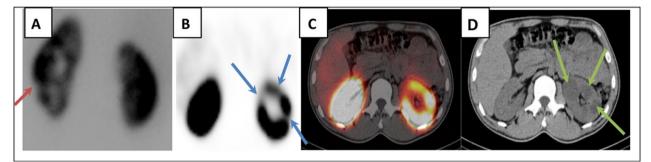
A 25-year-old, male patient, presented with left loin pain. A ^{99m}Tc-DMSA planar image (posterior view) demonstrating equivocal defect at the lower outer aspect of the left kidney (red arrow), B axial SPECT image revealed multiple left cortical defects (blue arrows), C the corresponding fused SPECT/CT and D the CT images shows that these defects are corresponding to multiple simple cortical cysts (yellow arrows)
